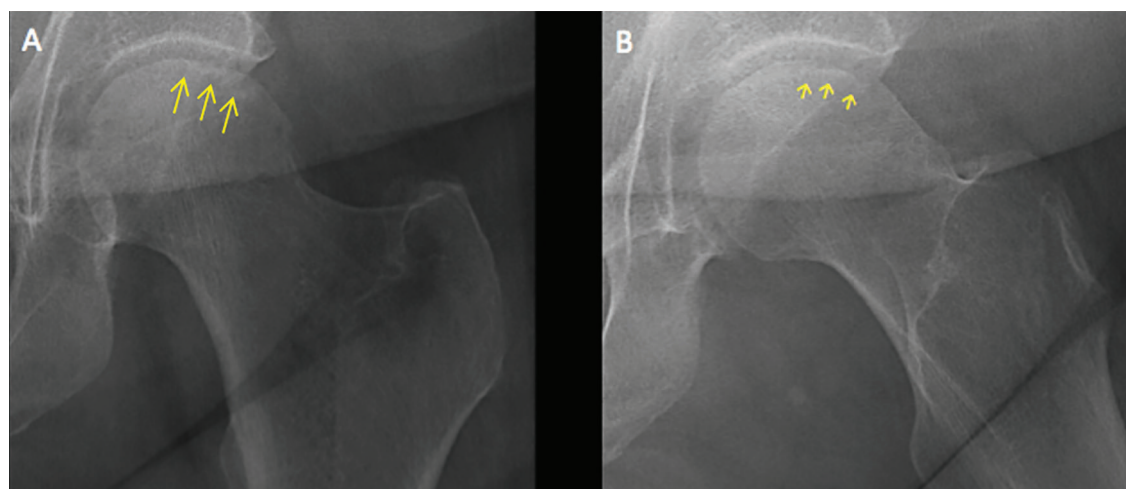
On plain radiography, a subchondral radiolucent line (arrows) was seen on internal rotation of the hip (A), and more clearly on external rotation (B) (arrows).
